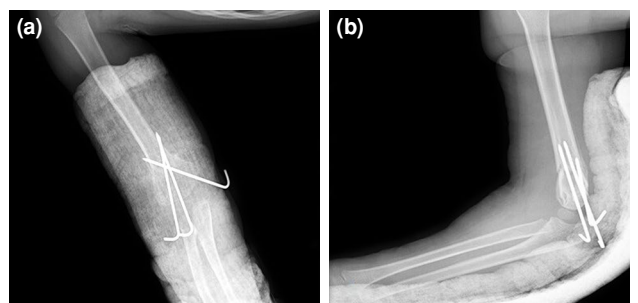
(a) Early anteroposterior and (b) lateral radiographic images of the case after closed reduction and long arm splinting.
